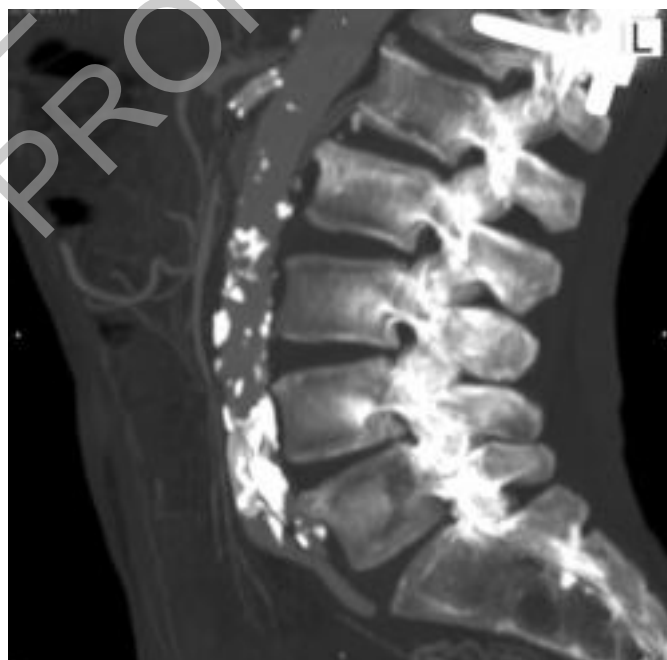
Maximal intensity projection CT Angiography at 5 months showing superior mesenteric artery stent occlusion with distal recanalization.
